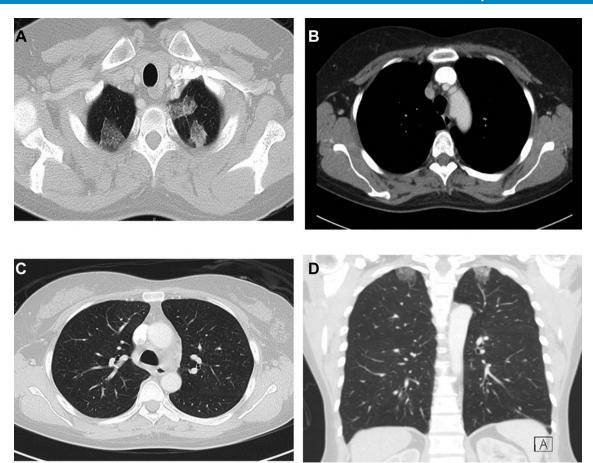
(A) Contrasted CT of the chest in the axial plane showing bilateral apical ground glass changes with thickening of the interlobular septa at the apices of both lungs, more marked over the apical segment of the left upper lobe. (B)Contrasted CT of the chest in the axial plane showing absence of ground glass changes and septal thickening in the midlung. (C)Contrasted CT of the chest in the axial plane (soft tissue window) showing lack of adenopathy. (D) Contrasted CT of the chest in the coronal plane showing upper lobe predominance of ground glass opacities.
